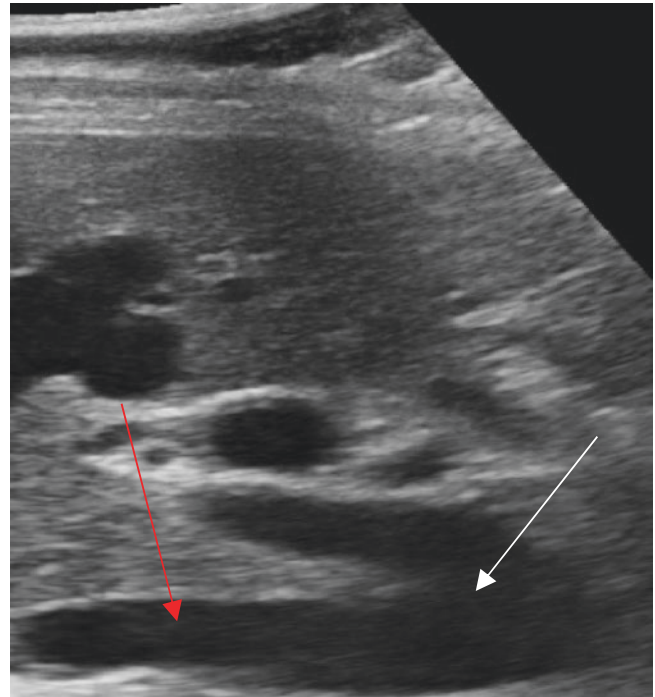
Ultrasonography aspect of dilated hepatic vein (red arrow) and dilated inferior vena cava (white arrow), signs of hepatic congestion
